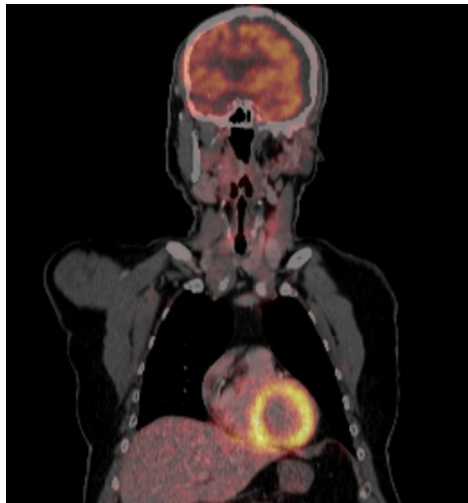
FDG PET/CT with minimal head movement between both investigations
